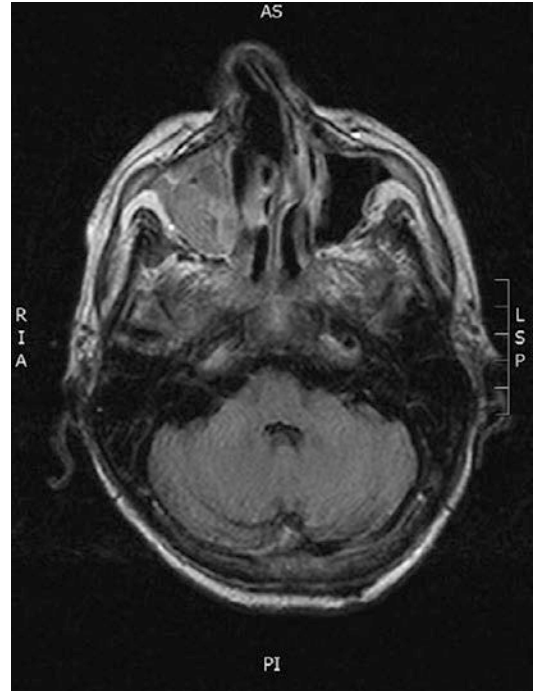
T1-weighted MRI
